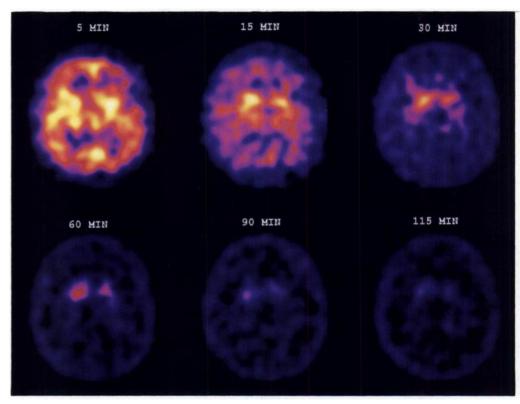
Activity distribution of <sup>123</sup>I-IPT after injection of 7.08 mCi (261.96 MBq) into a 49-yr-old man with early Parkinson's disease. Acquisitions were obtained for 5 min each with a triple-headed SPECT camera over 2 hr and reoriented so that the AC-PC line corresponded to the transaxial axis of the data set. Left BG-to-OCC ratios are 1.92, 2.85, 2.85 and 2.67 at 30, 60, 90 and 115 min, respectively. Right BG-to-OCC ratios were 2.27, 3.31, 2.53 and 3.46 at 30, 60, 90 and 115 min, respectively.
